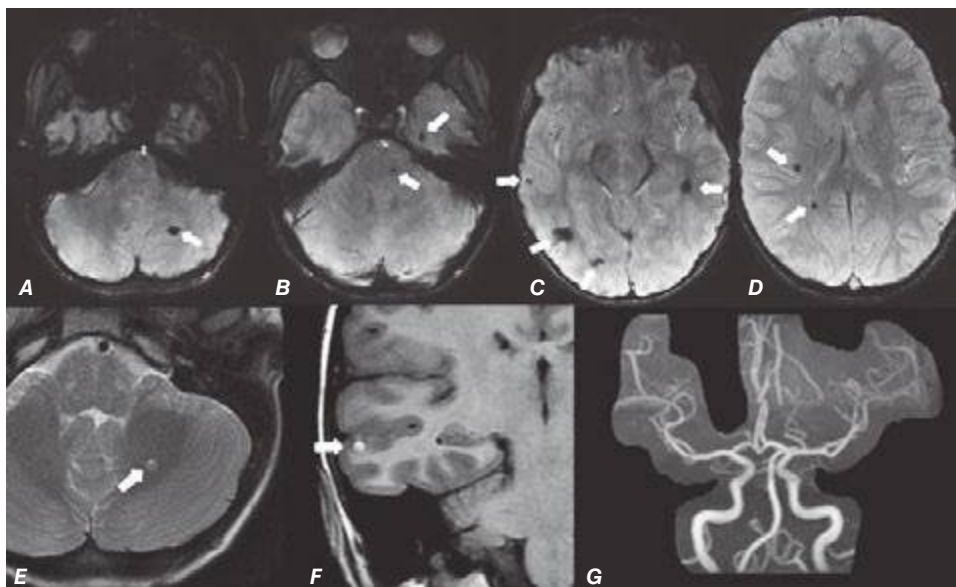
49 Multiple cavernomas (Chap. 446). Axial susceptibility weighted images (A–D) show multiple foci of susceptibility involving the bilateral cerebral hemispheres, pons, and left cerebellum, which in a young patient most likely represents multiple cavernomas (arrows). These lesions have variable signal intensity on T2-weighted (E) and T1-weighted MRI (F), related to the different stages of hemoglobin degradation (arrows). Cavernomas are not seen on the time-of-flight MR angiography (G); thus these are designated as angiographically occult vascular malformations. Of note, in elderly patients, amyloid angiopathy may have a similar appearance.
